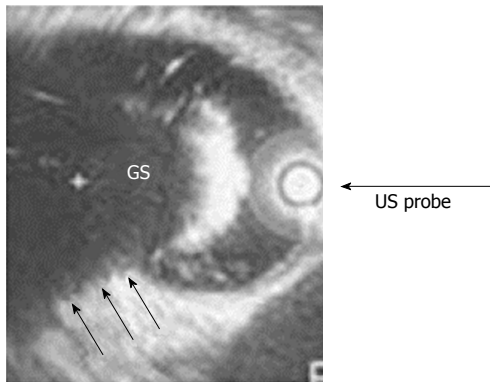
Intraductal ultrasound: Showing a gallstone in the common bile duct.
